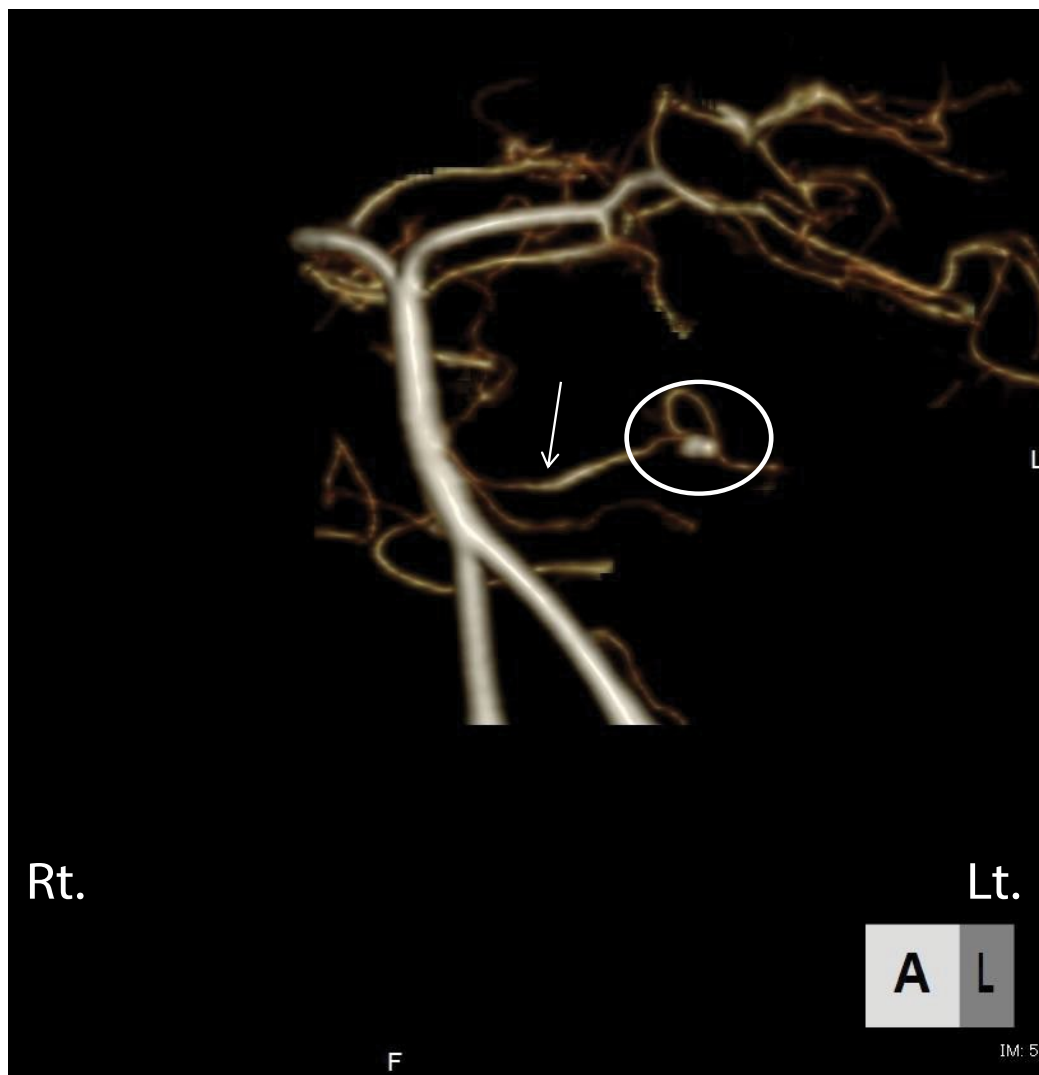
Computed tomography angiography revealed an aneurysm (circle) at the meatal loop of the left anterior inferior cerebellar artery (arrow). Lt.: Left; Rt.: Right
